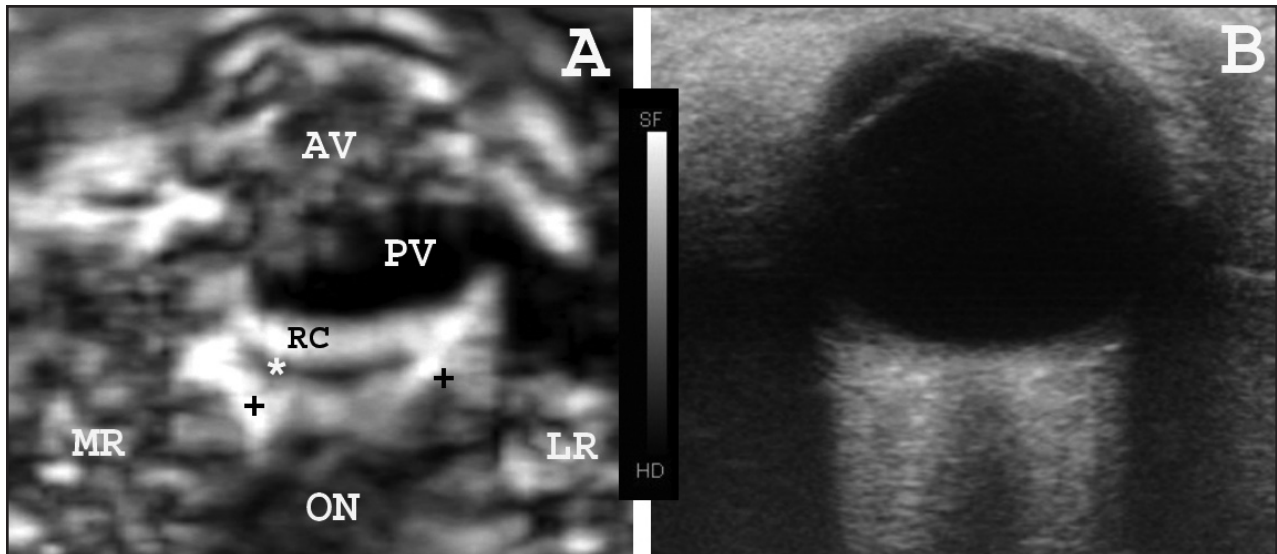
Grayscale ultrasound transverse elastographic image of (A) an eye and orbit and (B) corresponding B-scan image. The retina and choroid (RC) are presented with higher luminosity (more elastic) than the sclera (*). The intraconal fat pads (+) lateral and medial to the optic nerve are also shown with a higher luminosity (more elastic). The medial and lateral rectus muscle (MR and LR, respectively) and the optic nerve (ON) are shown with intermediate luminosity. The anterior vitreous cavity (AV) is shown with intermediate luminosity (intermediate elasticity) compared with the posterior vitreous cavity (lower luminosity and, therefore, lower elasticity). The gray scale from white (more elastic) to black (less elastic) is shown between A and B.
